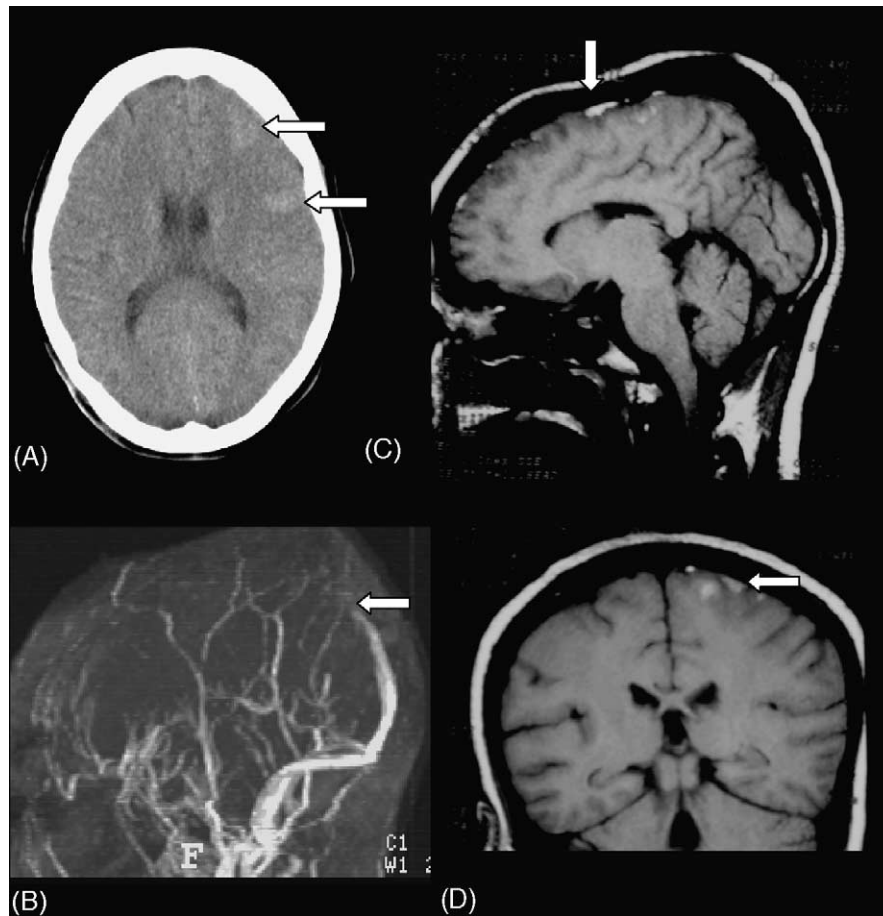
Imaging of patient (#4) with CVT during puerperium showing (A) cranial CT with an hemorrhagic infarct in the left frontal region (arrows); (B) MRV with signal dropout at the superior sagittal sinus (arrow); (C) sagittal T1 image (without gadolinium) showing a thrombus in the superior sagittal sinus and (D) coronal T1 image showing the thrombus and an hemorrhagic infarct (arrow).
